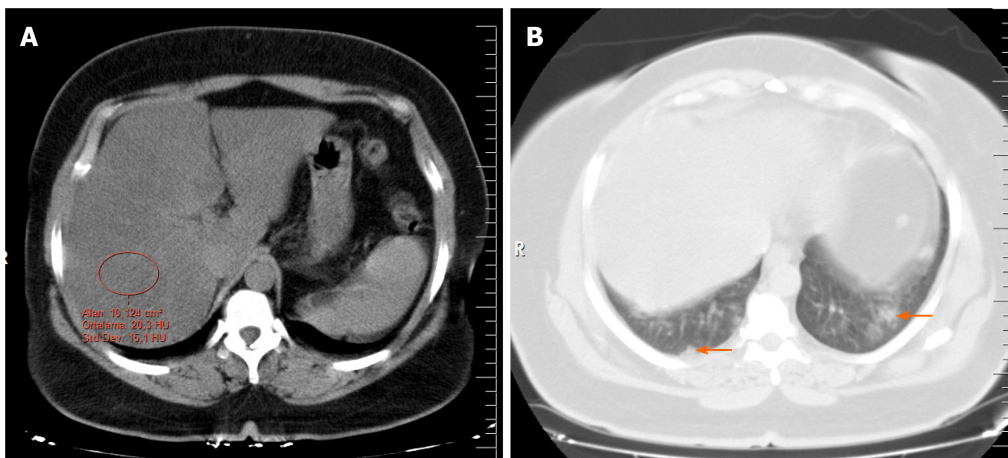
Noncontrast computed tomography of a patient with coronavirus disease 2019 accompanied by hepatic steatosis. A: The abdominal window shows the determination of the attenuation value with the measurement of a single region of interest (an area of approximately 10 cm²) from the right liver lobe (segment 7); B: Lung window demonstrating lesions (orange arrows) compatible with coronavirus disease 2019.
